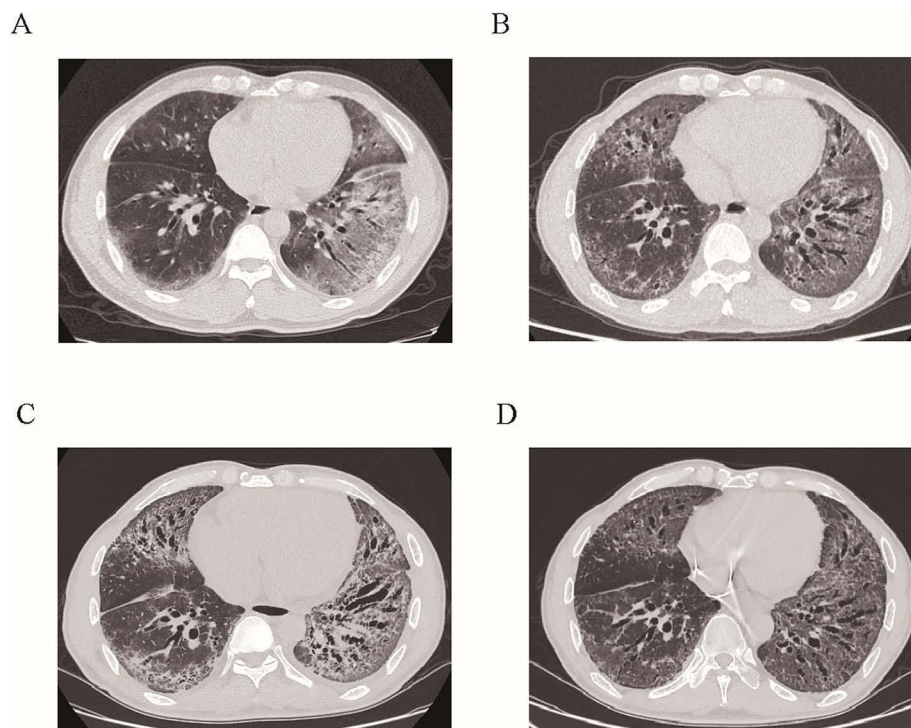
Chest-enhanced CT before and after treatment (A–D). (A) Bilateral pulmonary exudative lesions. (B) Diffuse interstitial changes and increased inflammatory lesions in both lungs. (C) Extensive progression of interstitial fibrosis and inflammation. (D) Decreased interstitial fibrosis and inflammation.
